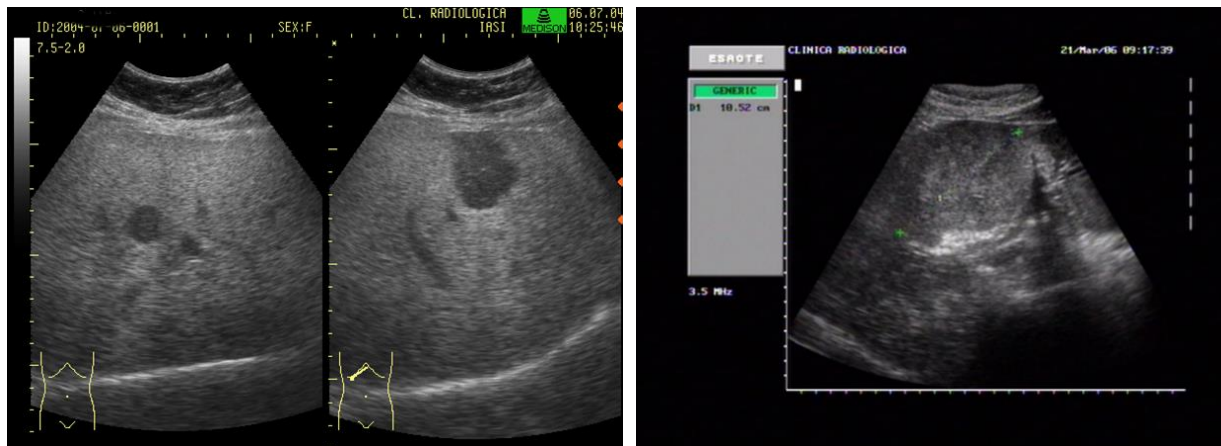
a) Liver ultrasound: multiple hypoechoic lesions – metastases; b) isoechoic metastasis
